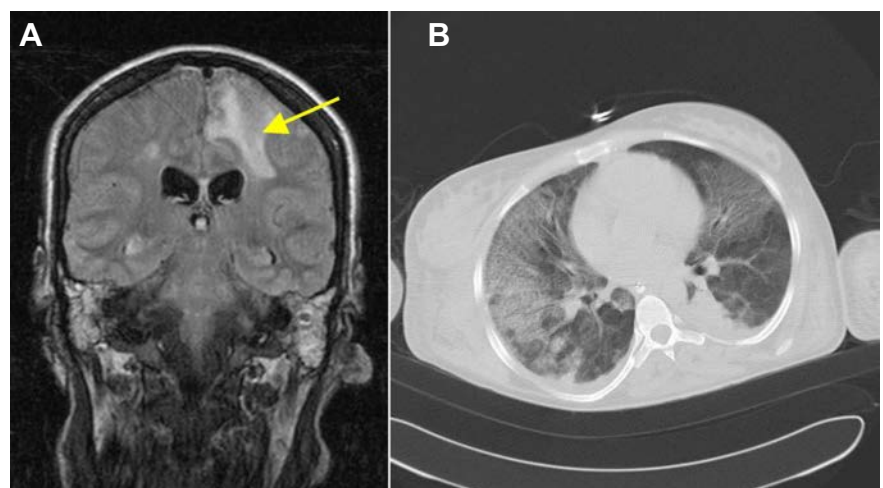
A) Cerebral septic embolism (MRI T2, frontal); B) Pulmonary septic embolism (CT scan, coronal).
